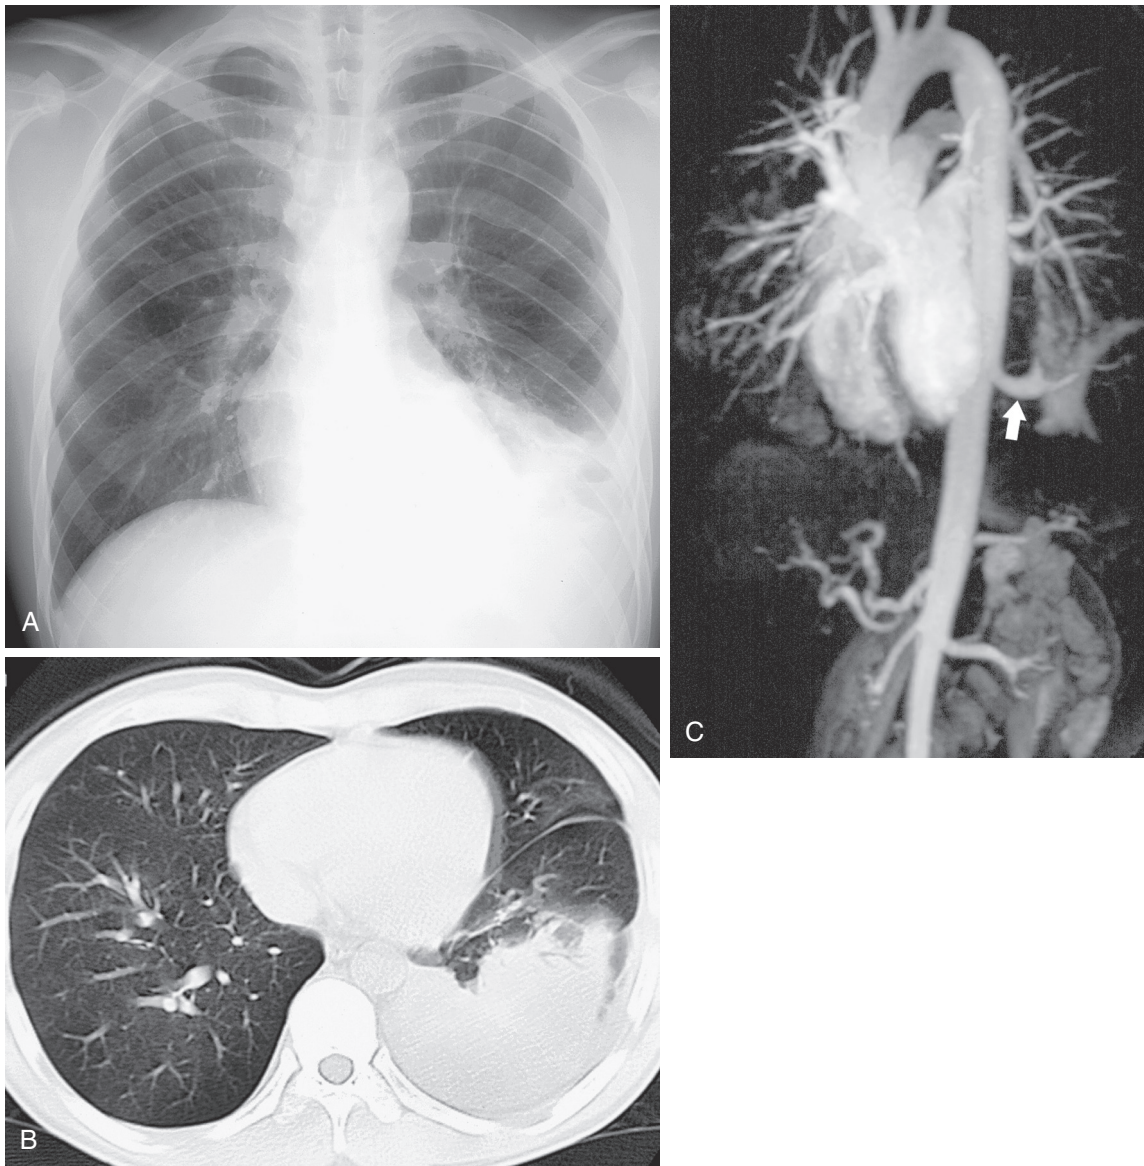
■ Intralobar pulmonary sequestration. A, Frontal chest radiograph shows consolidation of the left lower lobe. B, Computed tomography image of lung base shows opacification of the left posterior lower lobe. C, Contrast-enhanced magnetic resonance angiogram shows that a large arterial branch (*arrow*) arising from the low thoracic aorta supplies this region. (Courtesy Koji Takahashi, MD, Asahikawa Medical College, Asahikawa, Japan.)
